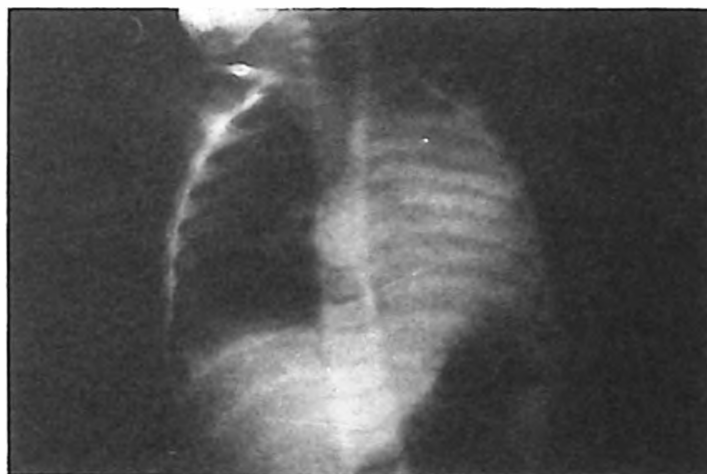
Atelectasia on the chest x-ray of a case with sunflower seed aspiration.
